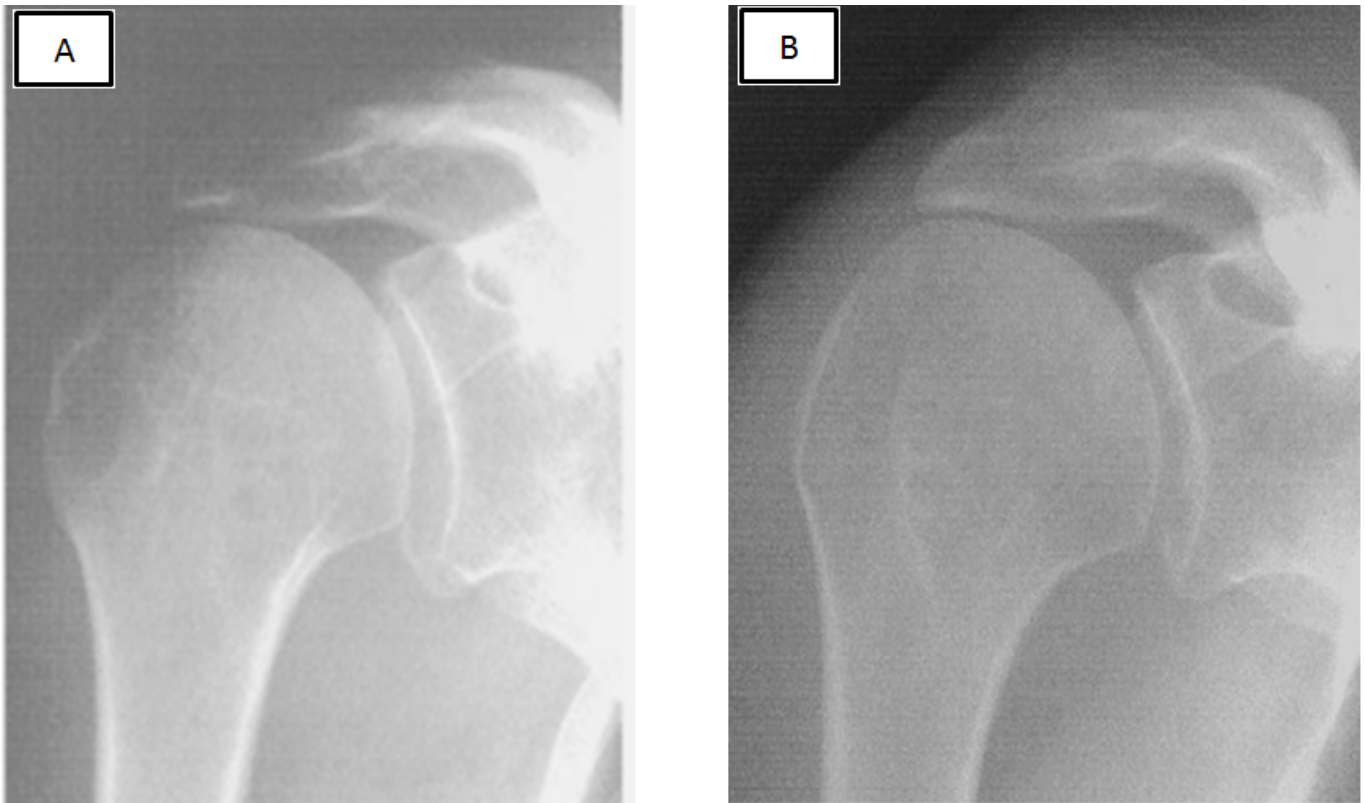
Anterior shoulder X-ray. A: before, B: after Tuberoplasty.
